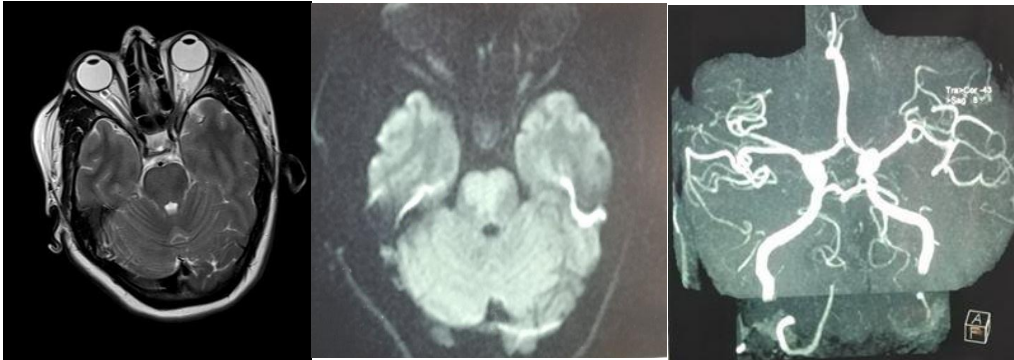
Cerebral MRI showing the thrombosis of left vertebral artery
